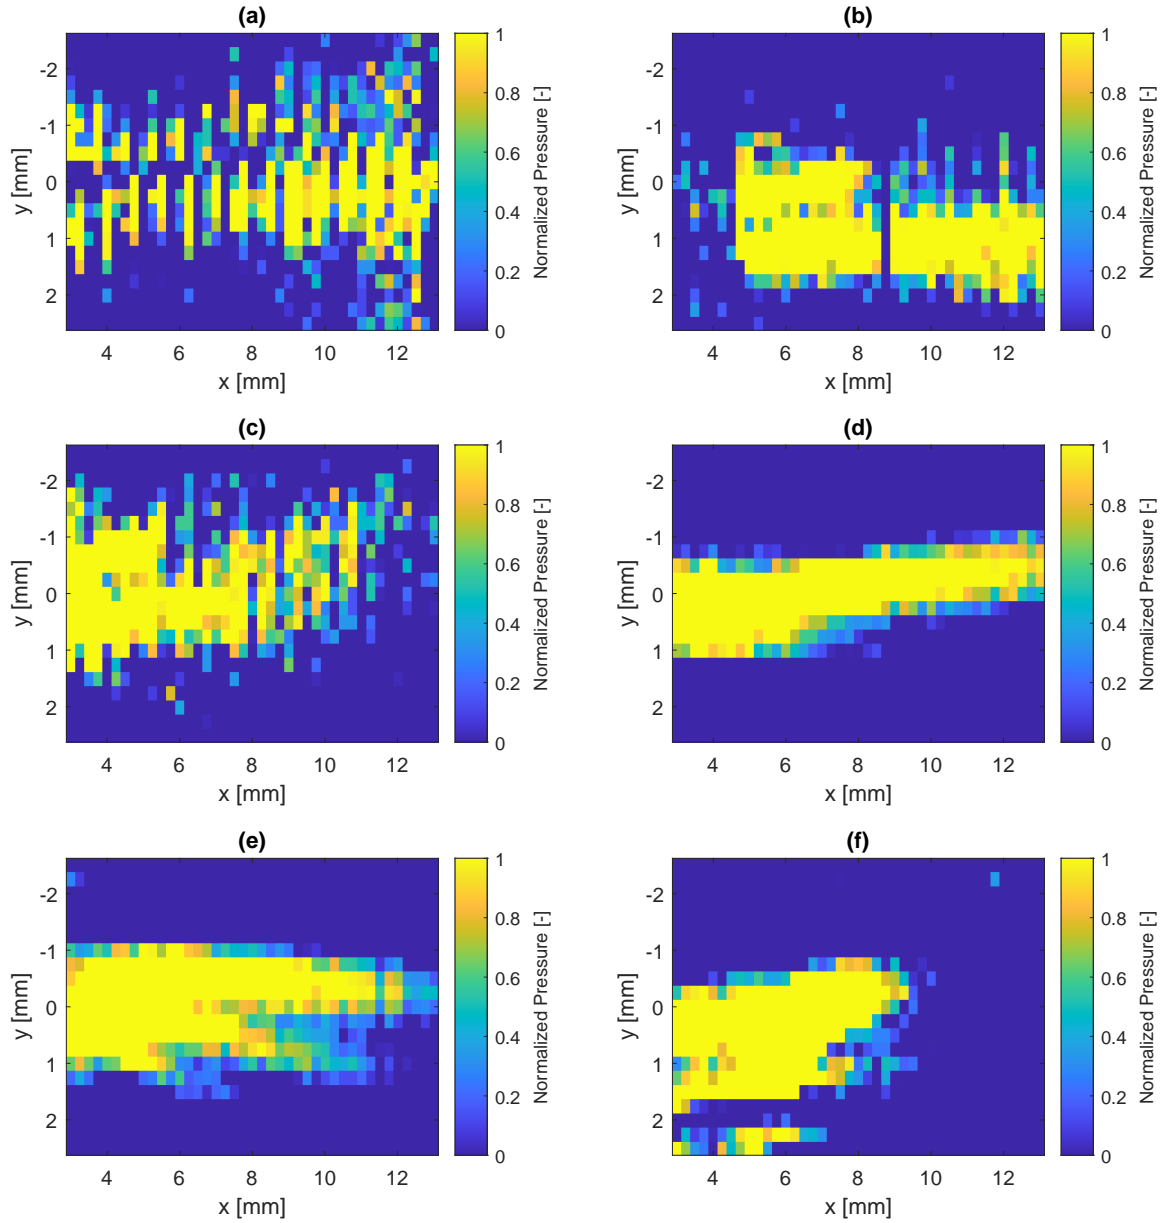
The normalized pressure field in the yz plane for all the examined transducers. Subfigures a) and b) present the data collected on ultrasound channel number 3 of Device number 1. Subfigures c) and d) present the data collected on ultrasound channel number 3 of Device number 2. Subfigures e) and f) present the data collected on ultrasound channel number 4 of Device number 2. Subfigures a), c), e) present the data collected with an electrode array fixed on the top of the transducer, while Subfigures b), d), f) present the data collected from the transducer on its own.
